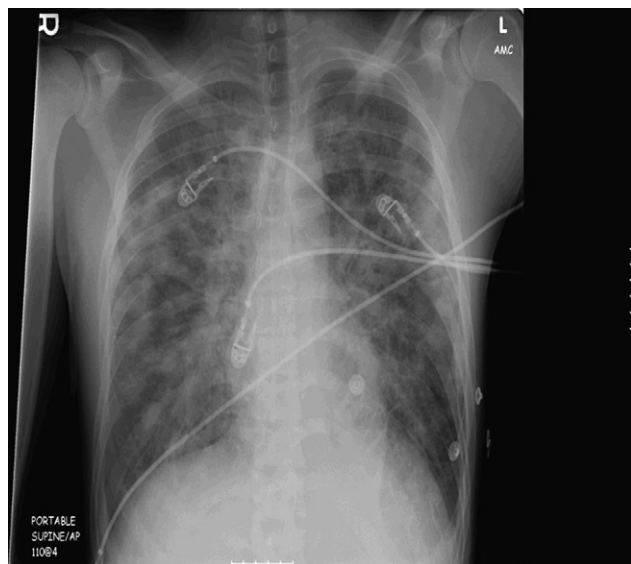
Chest radiograph of an HPS patient. Portable, supine AP chest radiograph of a patient in the cardiopulmonary phase at the time of presentation to the critical care unit, showing diffuse alveolar filling and small, bilateral pleural effusions. The size of the cardiac silhouette appears normal. Within hours the patient required mechanical ventilation and extracorporeal membrane oxygenation (ECMO). Courtesy G. Mertz, University of New Mexico.
